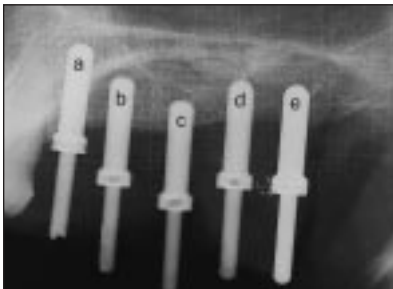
Radiographic presentation of orientation drill (a) control site (b) test sites c to e.
